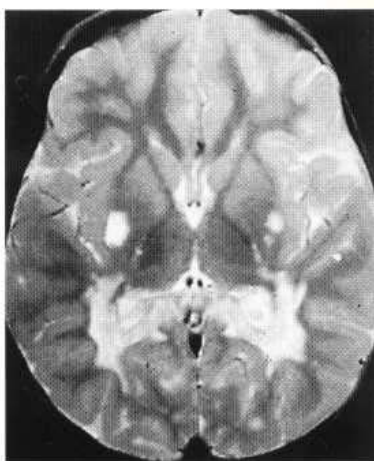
Mitochondrial cytopathy. Four-year-old boy with ataxia, myoclonus and drowsiness. MRI (T₁-weighted) reveals loci of high signal in the lentiform nuclei and parietal white matter extending into posterior limbs of internal capsule.
